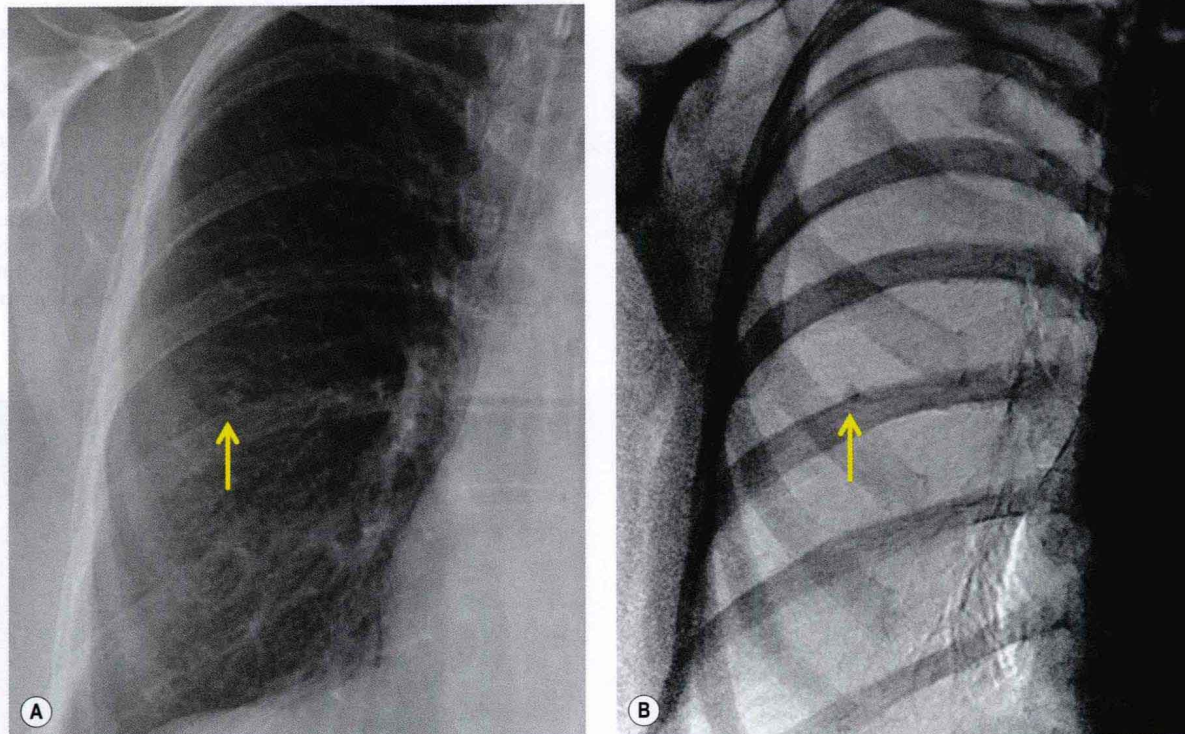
Dual-energy subtraction. A, Frontal chest radiograph shows right lung nodule (arrow) in a TB-exposed patient. B, Soft tissue subtracted image confirms that the nodule is calcified (arrow) and thus likely to represent granuloma. (Courtesy of H Page McAdams, Durham, NC, USA.)
